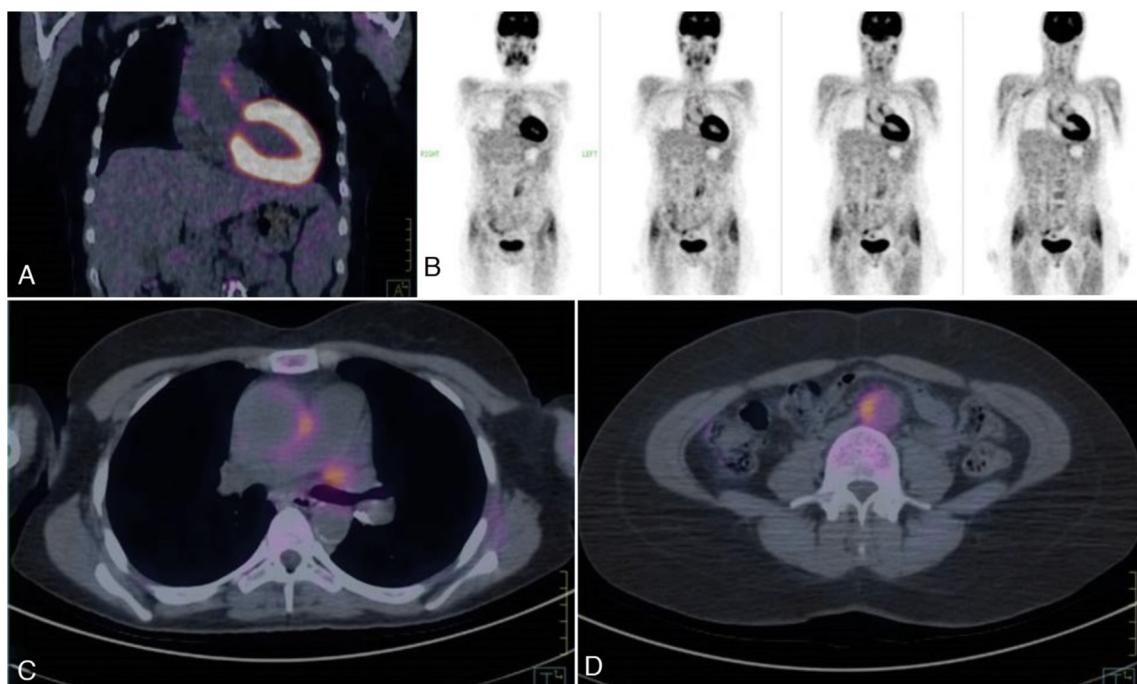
Representative PET-CT scan images from a patient with Takayasu arteritis and active disease.
